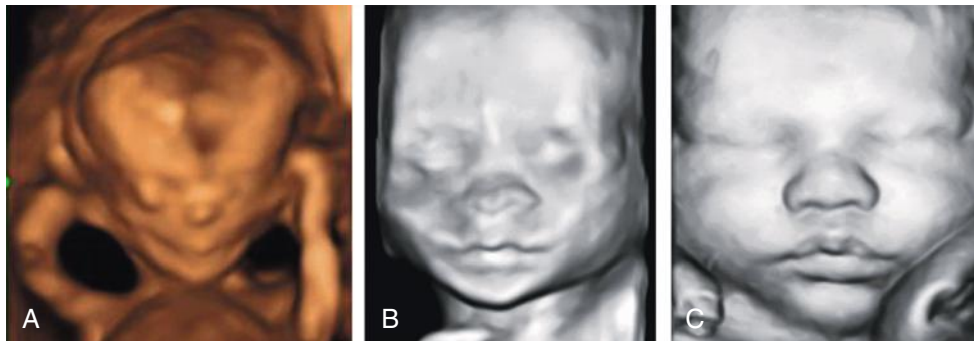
Three-dimensional ultrasound images of fetal face. Surface rendering of the fetal face at 11 weeks (A), 19 weeks (B), and 37 weeks (C).
